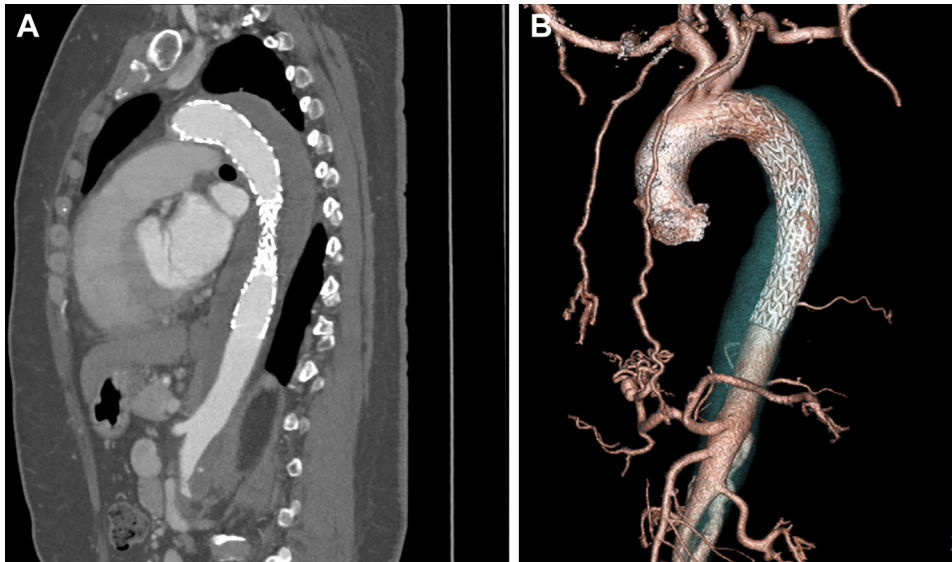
Postoperative computed tomography (CT) angiography at 3-month follow-up. A, Complete thrombosis is shown from the distal aortic arch to the descending aorta with no dilation of the dissecting aortic aneurysm. The patent false lumen is seen from the abdominal aorta to the proximal common iliac artery. B, Three-dimensional CT angiogram.
